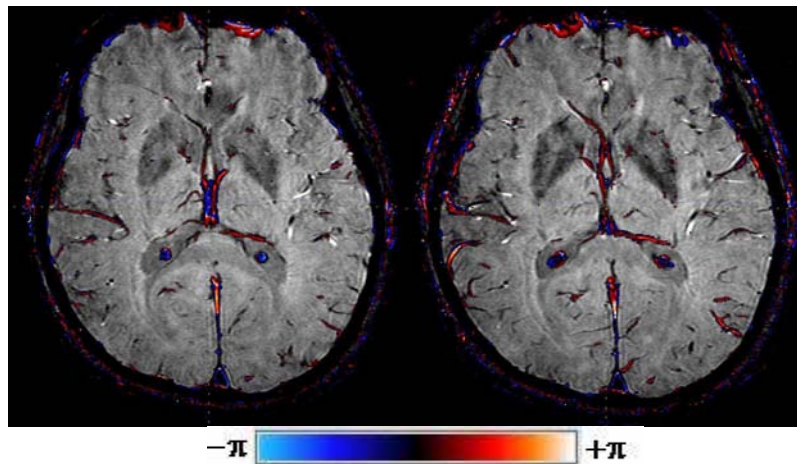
Phase weighted Image: Phase difference is mapped in to color scale and overlapped in the two sequential 2D axial MR image slices.
